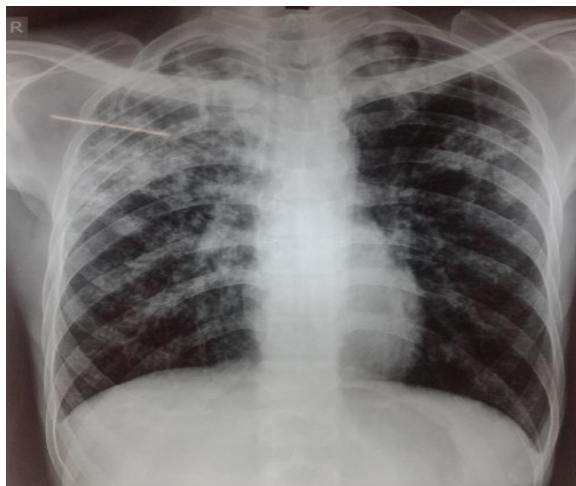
Chest radiography showing ill defined bilateral extensive opacities.
